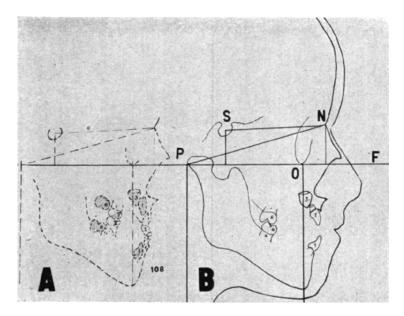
Tracings from roentgenograms of the same child shown in Figure 18 taken two years apart. Note the relations of the teeth and jaws to the anterior-posterior base planes, PF, PN, SN, and to the vertical planes through P and O.
